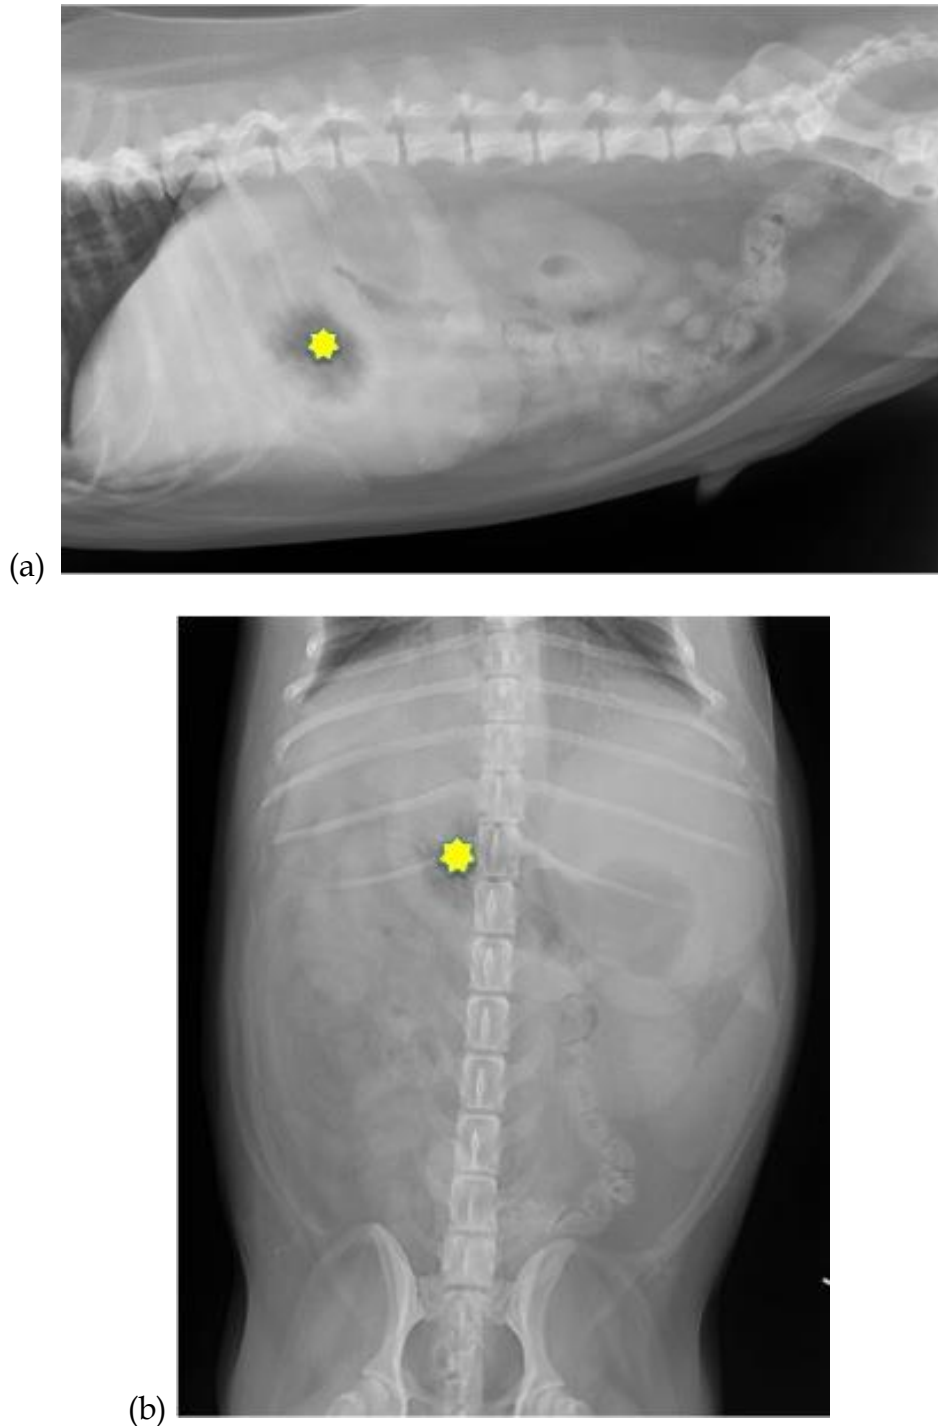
The plain, right lateral (a) and ventrodorsal (b) radiographs showed the moderate degree of gastric dilatation with fluid that mostly found at the fundus area on both views and radiolucent gas content at the pylorus (asterisk).
